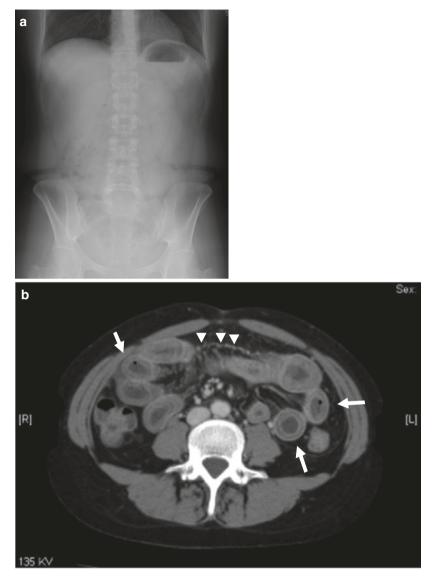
Radiologic findings from case 1. (a) A plain abdominal radiograph shows air-fluid levels with little quantity of air. (b) A contrast-enhanced CT scan image. The arrows indicate the "target sign" which consists of distension of the small bowel with marked thickening of the wall and enhancement of the mucosa and serosa. The triangles indicate the "comb sign" which consists of dilatation of intestinal segments and engorgement of mesenteric vessels
